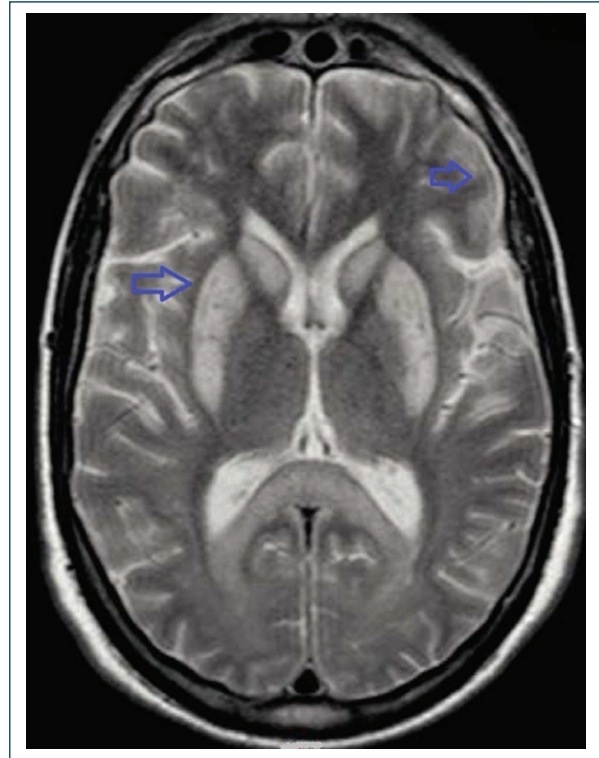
Magnetic resonance imaging axial section in T2 sequence highlights hyperintensity in basal ganglia and dedifferentiation of white and gray matter.
